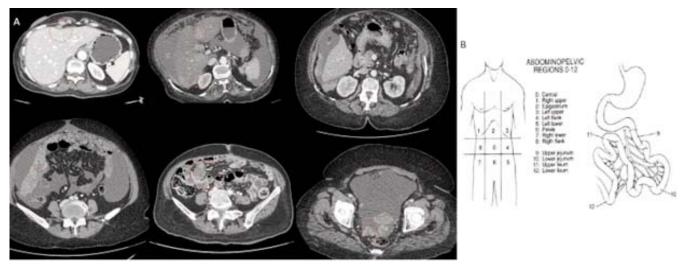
(A) Axial contrast computed tomograpgy (CT) sections of the abdomen showing subcapsular, intrahepatic fissure, Morison's pouch, omental, mesenteric, cul-de-sac deposits. (B) Measurement method of Peritoneal Carcinomatous index (PCI) estimation.
